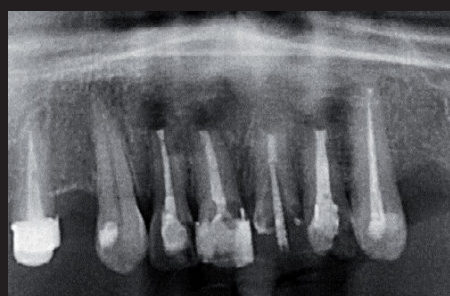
Panoramic radiograph – anterior maxilla
